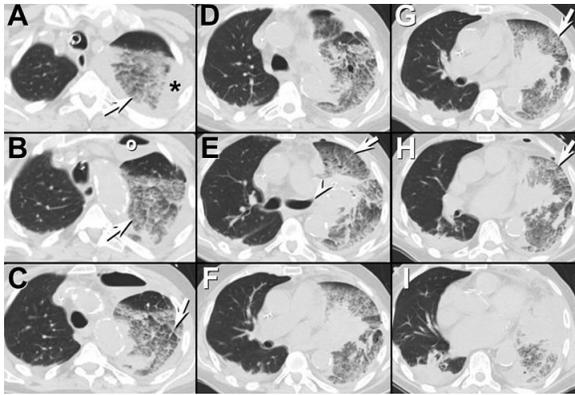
Axial unenhanced chest CT shows extensive left lung ground-glass opacity following left upper lobectomy associated with extensive left lung interlobular septal thickening (arrows). Dense central left lung consolidation is present associated with a truncated bronchus; the left lower lobe bronchus is not readily seen. A small anterior left upper chest pleural effusion (*) and post-operative hydropneumothorax (°) are present.
